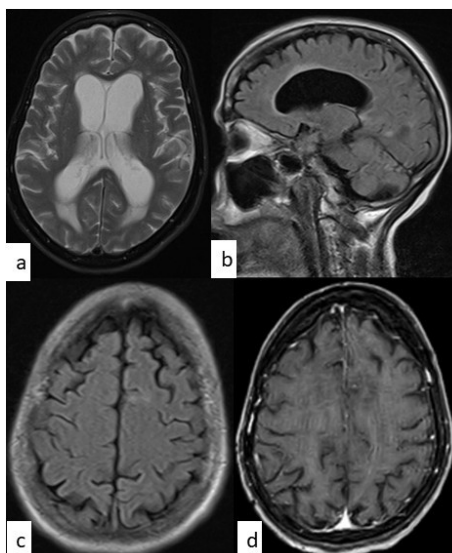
Brain MRI at presentation showing communicating hydrocephalus with interstitial edema on axial T2W image (a); subtle periventricular FLAIR hyperintensity (b, c); no enhancement on GAD-enhanced T1W image (d).
